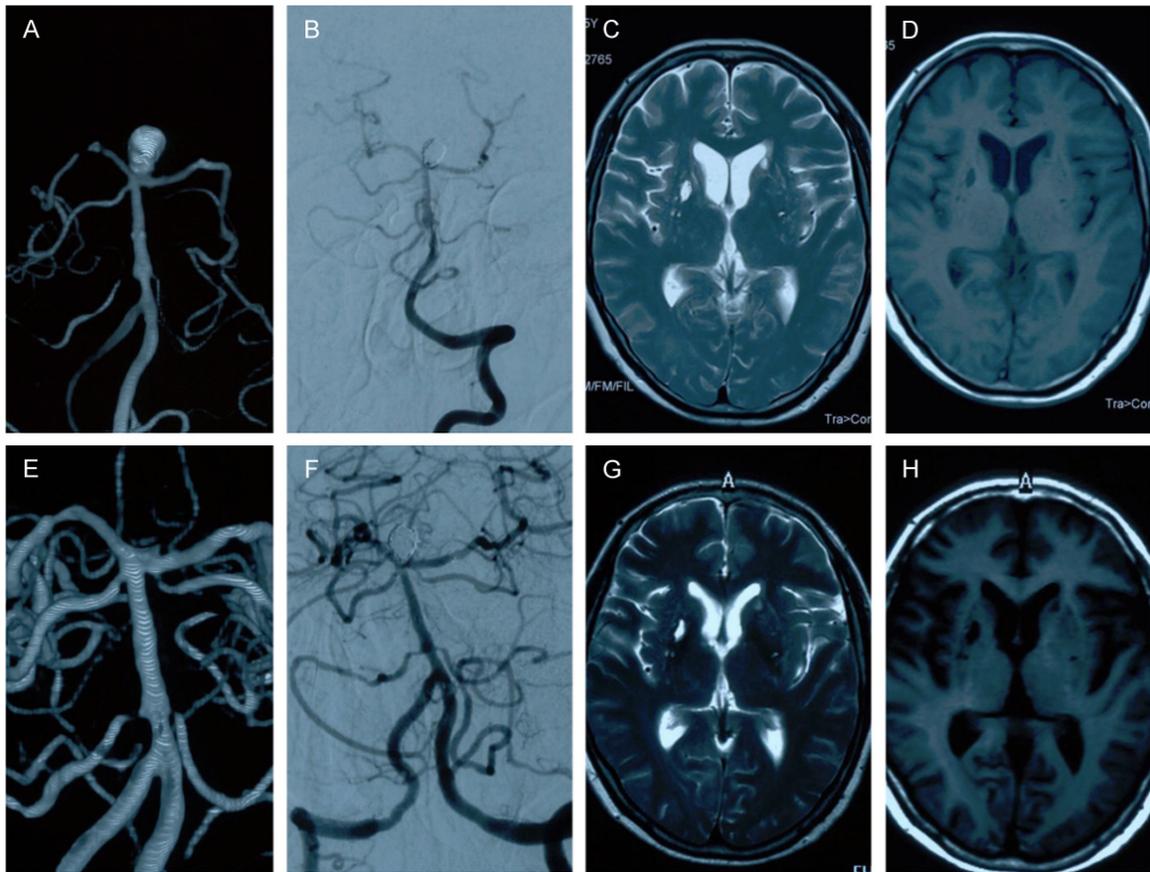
Follow up images. Aneurysm recurrence and parent artery stenosis were not observed at 3 months post-operative. NMI showed multiple obsolete infarcts of the bilateral thalamus (A. 3D without subtraction; B. 2D with subtraction; C. T2 image; D. T1 image); A 20-month postoperative review did not detect aneurysm recurrence or parent artery stenosis; MRI showed multiple obsolete infarcts of the bilateral thalamus (E. 3D with subtraction; F. 2D with subtraction; G. T2 image; H. T1 image).
